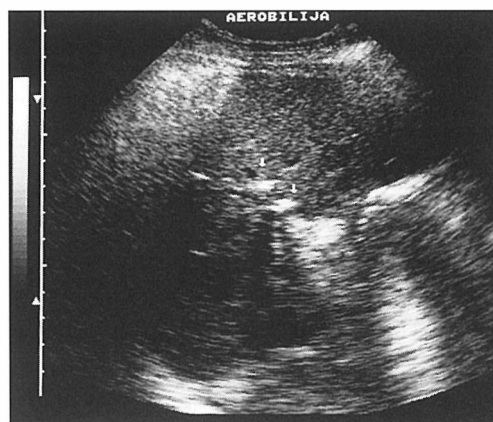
Ultrasonogram showing pneumobilia.
